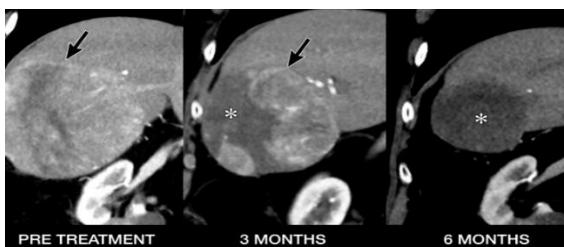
CT scan demonstrating tumor response after TARE. Baseline CT shows cirrhosis with hepatocellular carcinoma (arrow) involving liver segments V–VIII. The three-month post-treatment CT reveals substantial intratumoral necrosis, indicating a partial tumor response. Six months later, follow-up imaging demonstrates near-complete necrosis, consistent with a sustained and effective therapeutic response.
